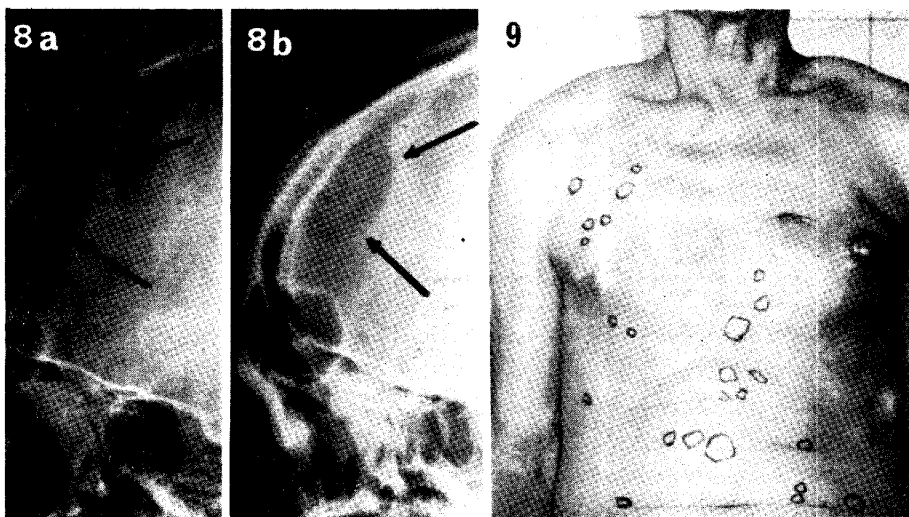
Skull x-rays (case 6) indicating a punched-out lesion (arrows; seen in the 8a before treatment, and the same lesion in the 8b with reduced radiolucency with focal calcification after the treatment.
